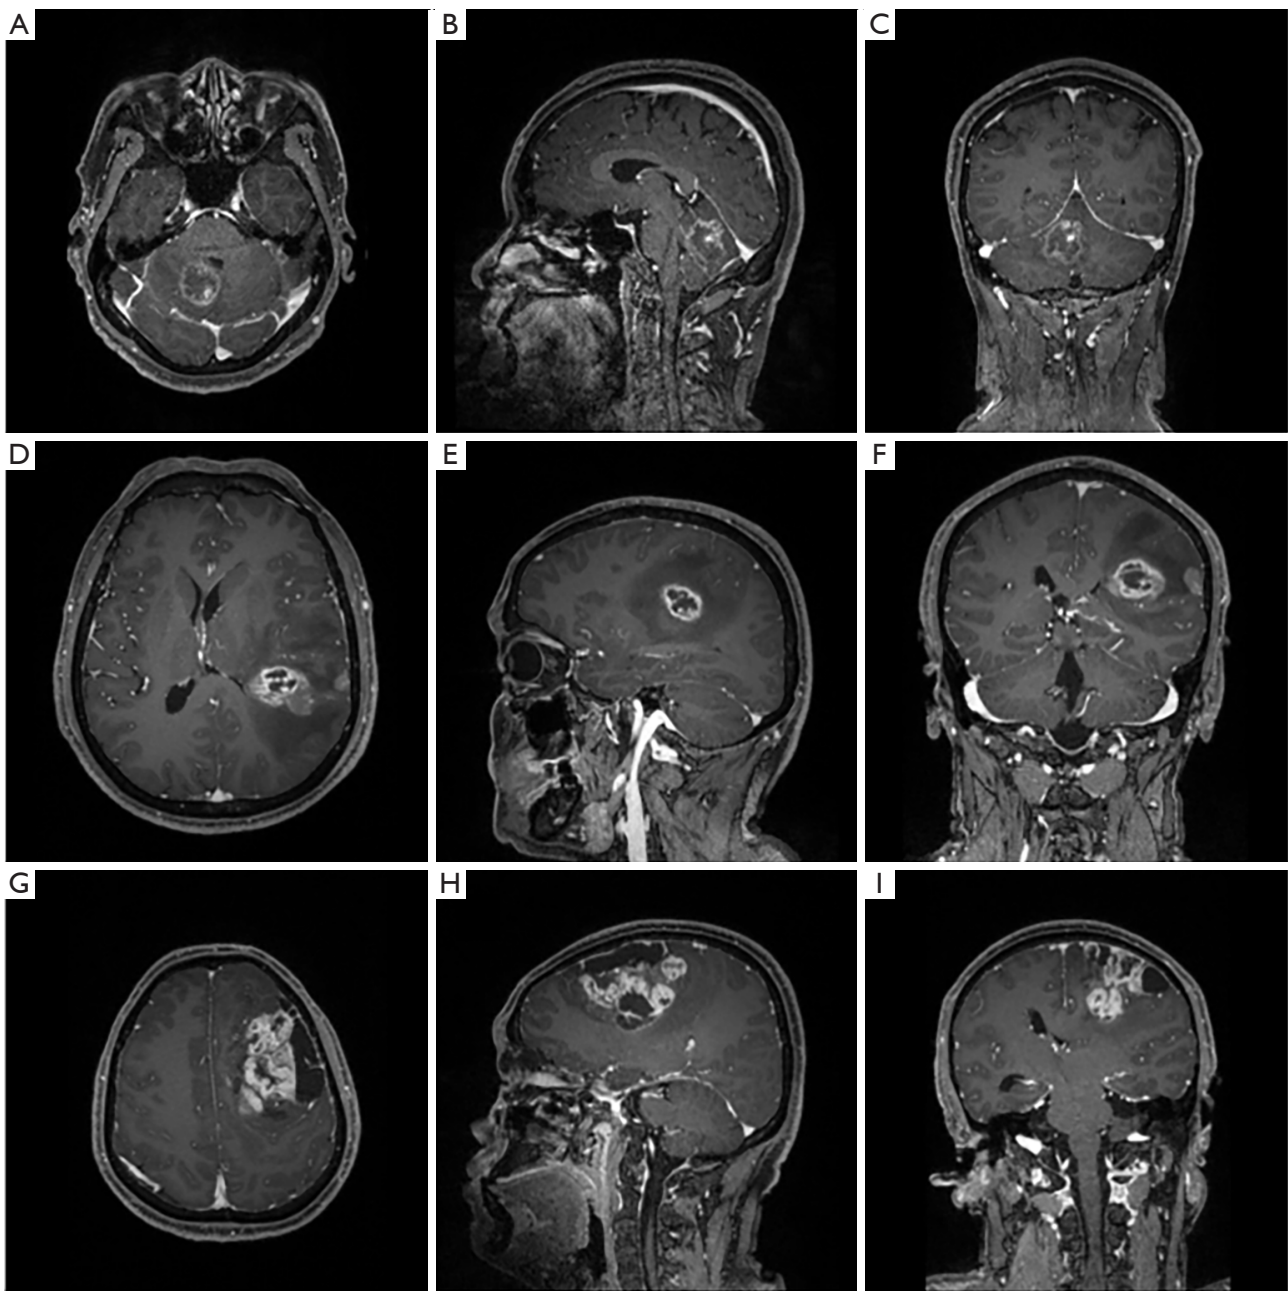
Three cases for contrast-enhanced MRI images of high-gliomas. (A-C) Patient with GBM in (A) axial, (B) parasagittal, and (C) coronal view. (D-F) Patient with AA in (D) axial, (E) parasagittal, and (F) coronal view. (G-I) Patient with AO in (G) axial, (H) parasagittal, and (I) coronal view. MRI, magnetic resonance imaging; GBM, glioblastoma; AA, anaplastic astrocytoma; AO, anaplastic oligodendroglioma.
